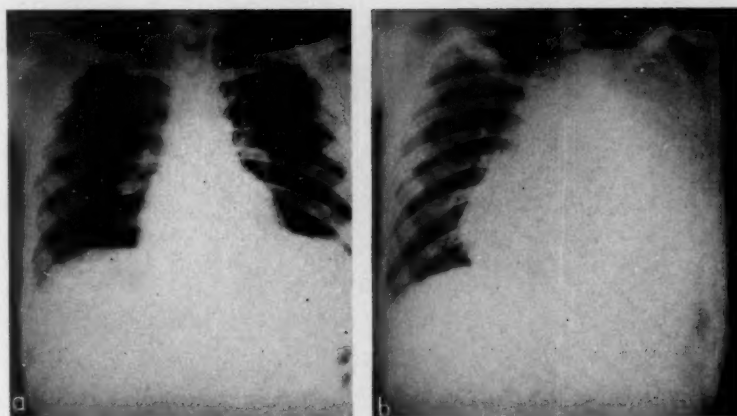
(a) Postero-anterior radiograph showing elevation of the left diaphragm with pleural reaction at the left base. (b) 11 days after (a), showing rupture (via the anterior mediastinum) into the left pleural cavity. Two pints of pus were aspirated, and air instilled. Note the air-fluid level near the apex
